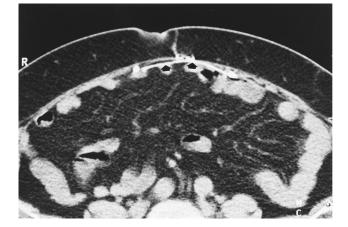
CT of the abdominal wall shows a Gore-Tex Dual Mesh secured with sutures (*arrows*).
